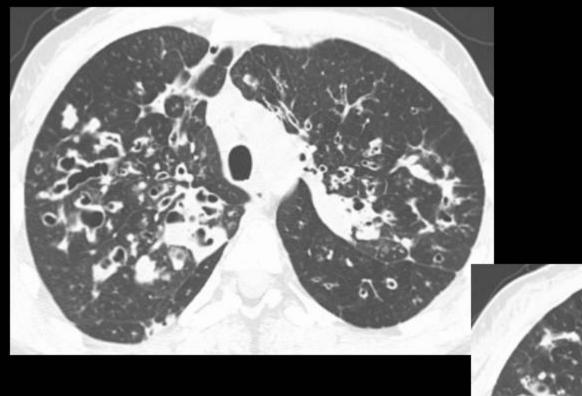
Woman, 24 years old, with cystic fibrosis, productive cough and blood streaked sputum. Thoracic CT shows multiple, diffuse and thickened cystic and varicose bronchiectasis, some with air-fluid level or completely filled.
